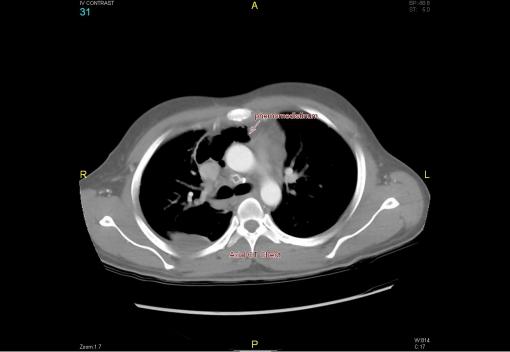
Axial CT Chest: Showing Pneumomediastinum.
